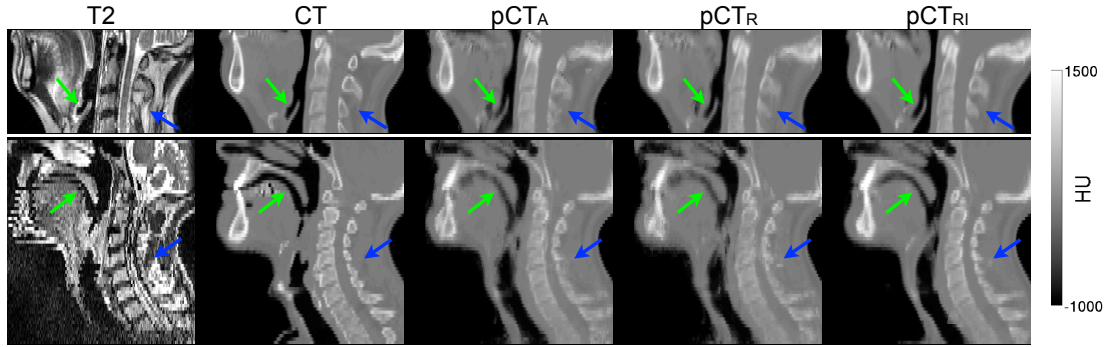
Examples of T2-w MRI, CT, and pseudo CT images for a subject from dataset 1 (top) and dataset 2 (bottom). pCT_A was obtained using a single affine transformation between the atlases and target, pCT_R using the robust affine transformation and pCT_{RI} after the robust affine transformation and the iterative bone refinement. Note that the method is able to generate a pseudo CT even in the presence of motion and large-scale postural changes such as neck flexion.
